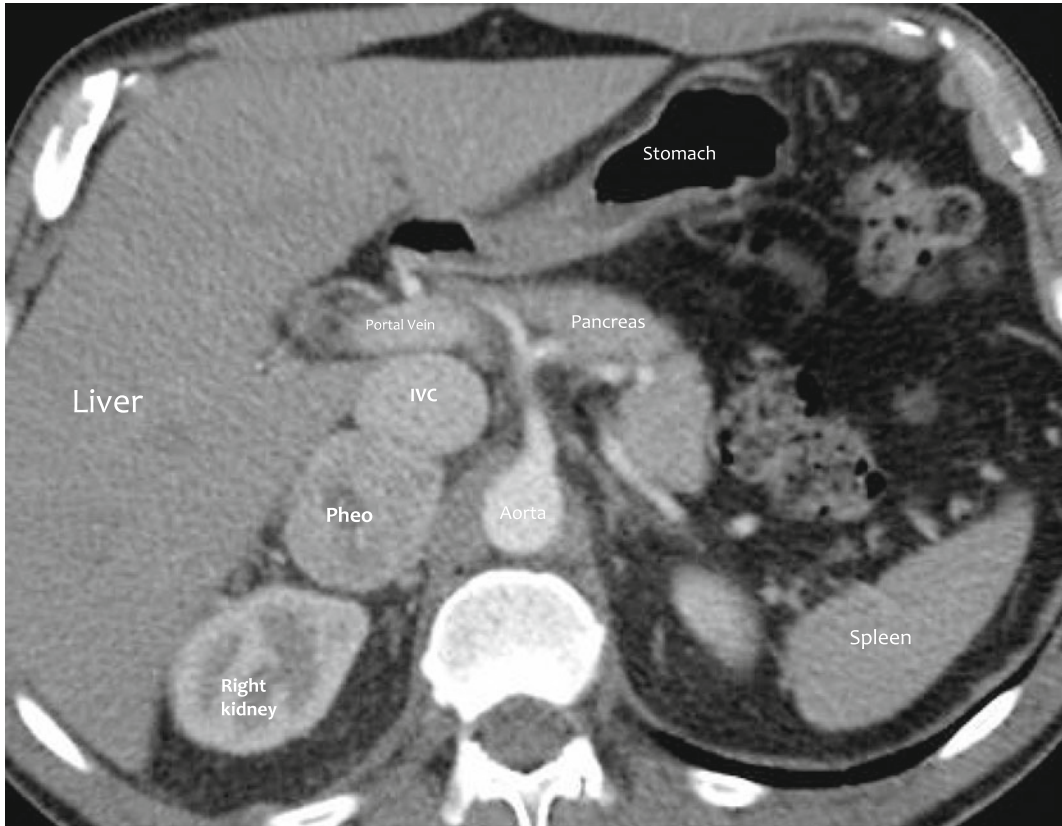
Axial CT image of a right adrenal pheochromocytoma, which was removed through a right anterior laparoscopic approach as it is on the upper range of size to
